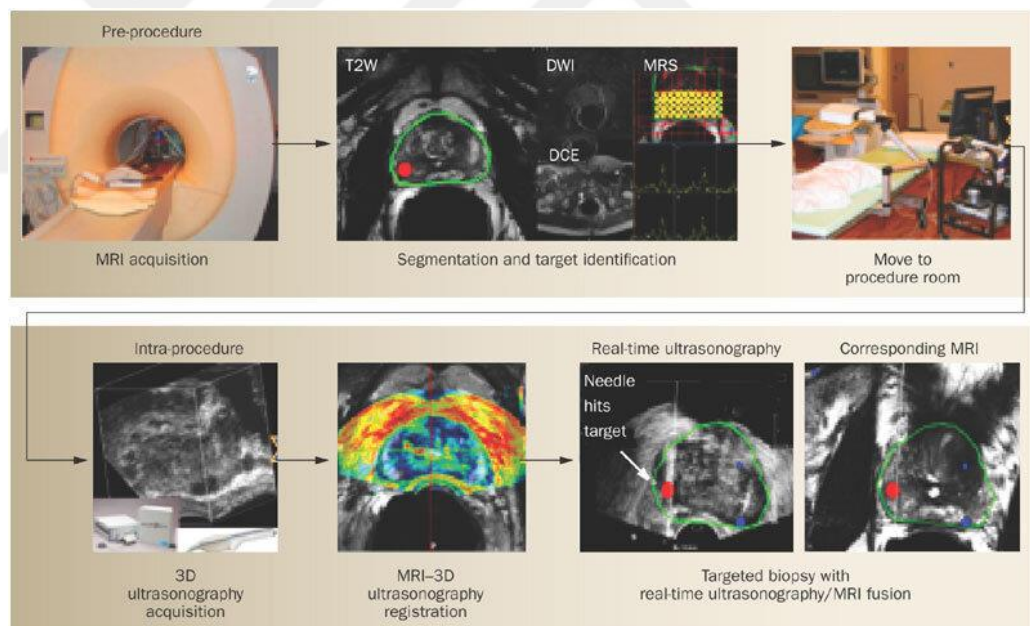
Workflow of MRI-TRUS(Ultrasound) Fusion Biopsy method (Turkbey, B., et al., 2009).
